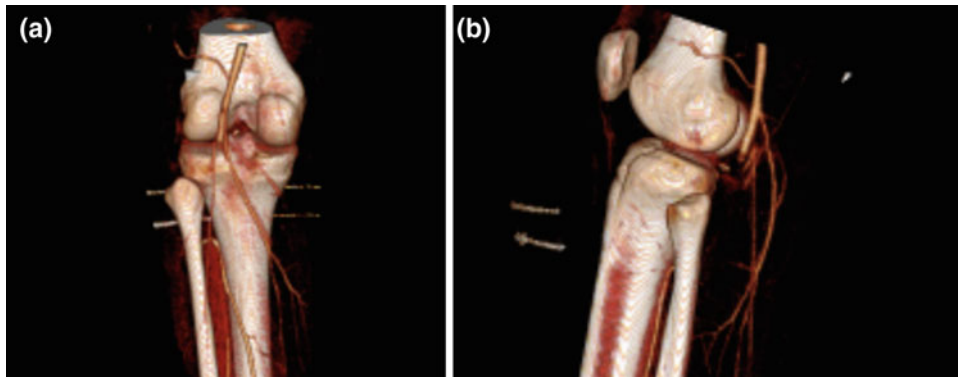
Coronal (a) and sagittal (b) reconstructions of a CT angiogram demonstrating popliteal artery injury in the setting of a KD III knee dislocation
